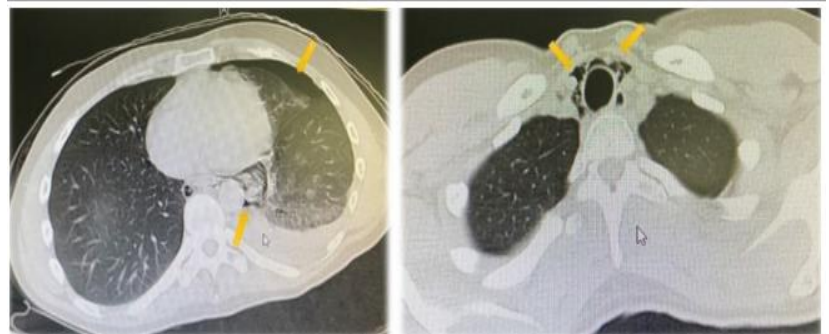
Axial image of CT chest showing left pneumothorax and pneumomediastinum (yellow arrows).
